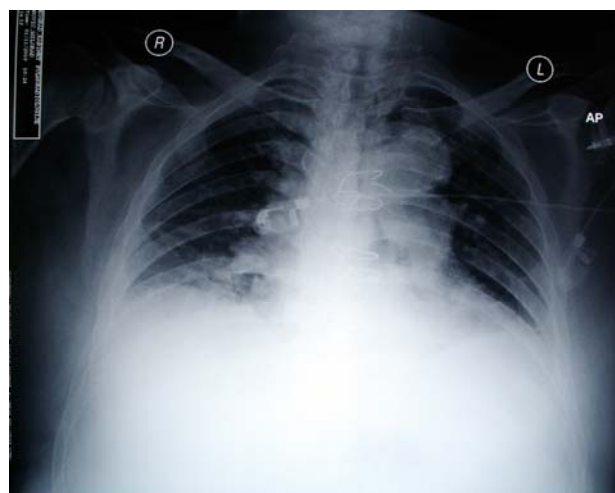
Chest radiography showed enlarged cardiac silhouette and the voluminous hilum.
